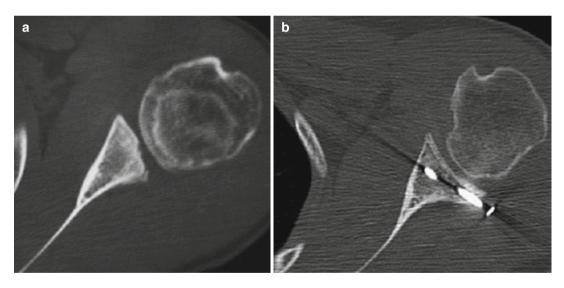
Axial CT images. (a) Posterior glenoid bone loss. (b) Postoperative image after reconstruction with distal tibia allograft (Reprint with permission; Millett et al. [31])
